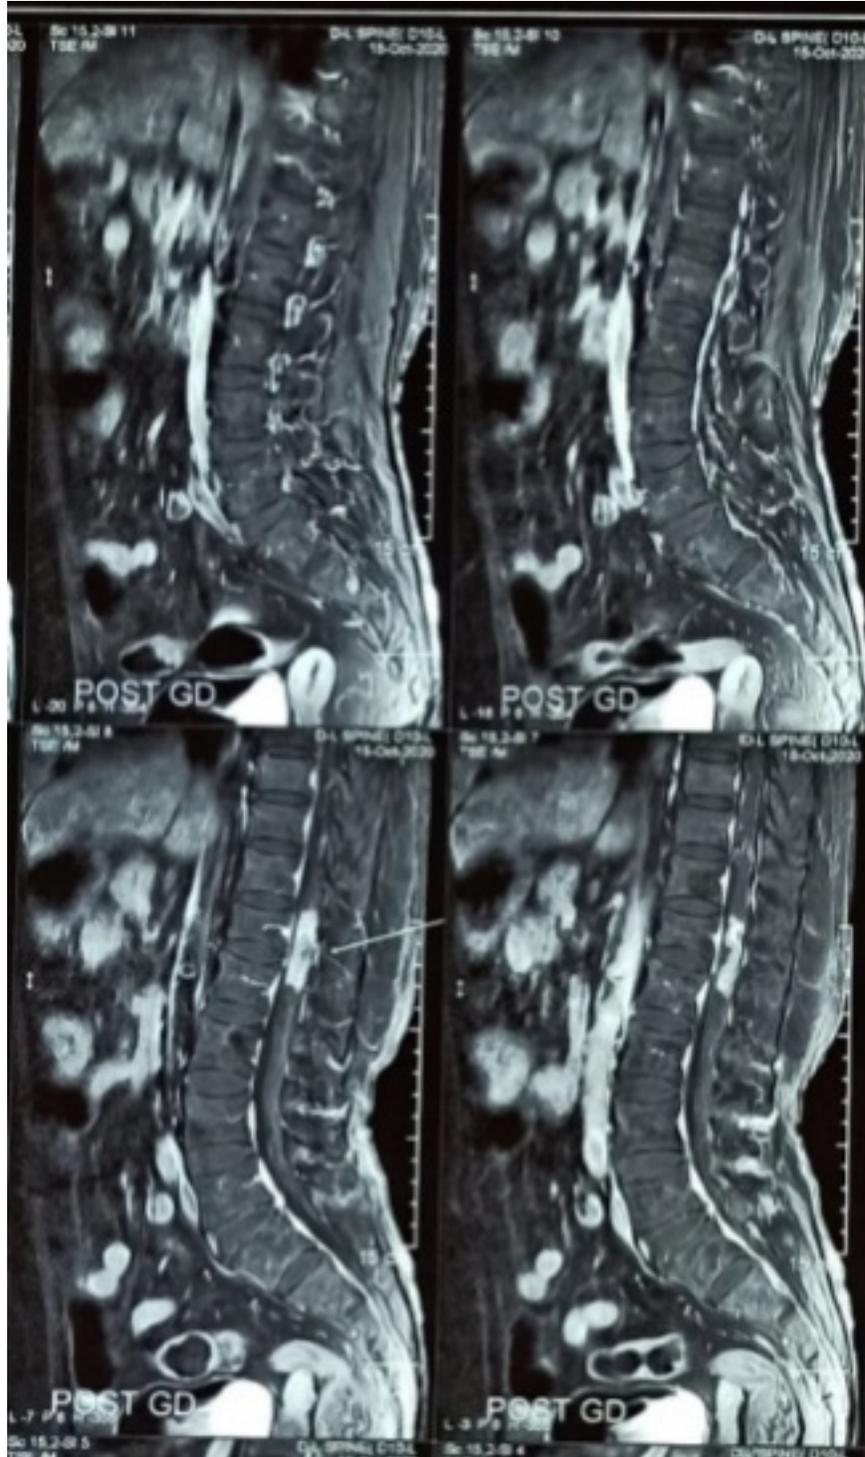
Sagittal view of T2 weighted Contrast MRI showing intramedullary mass at thoracolumbar level
